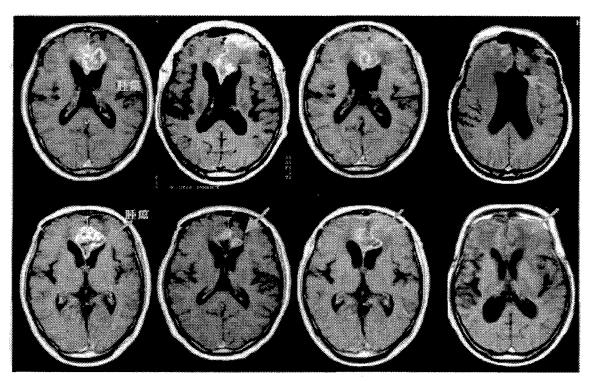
A 65-year-old man with glioblastoma was underwent in March, 1995 at JRR-2. Follow up MRI BNCT (from leftto right; pre BNCT, 2weeks, 1 month, 6 months after BNCT) Radiation dose at target pint was 11Gy. Abnormally enhanced lesion gradually decreased (arrow).
